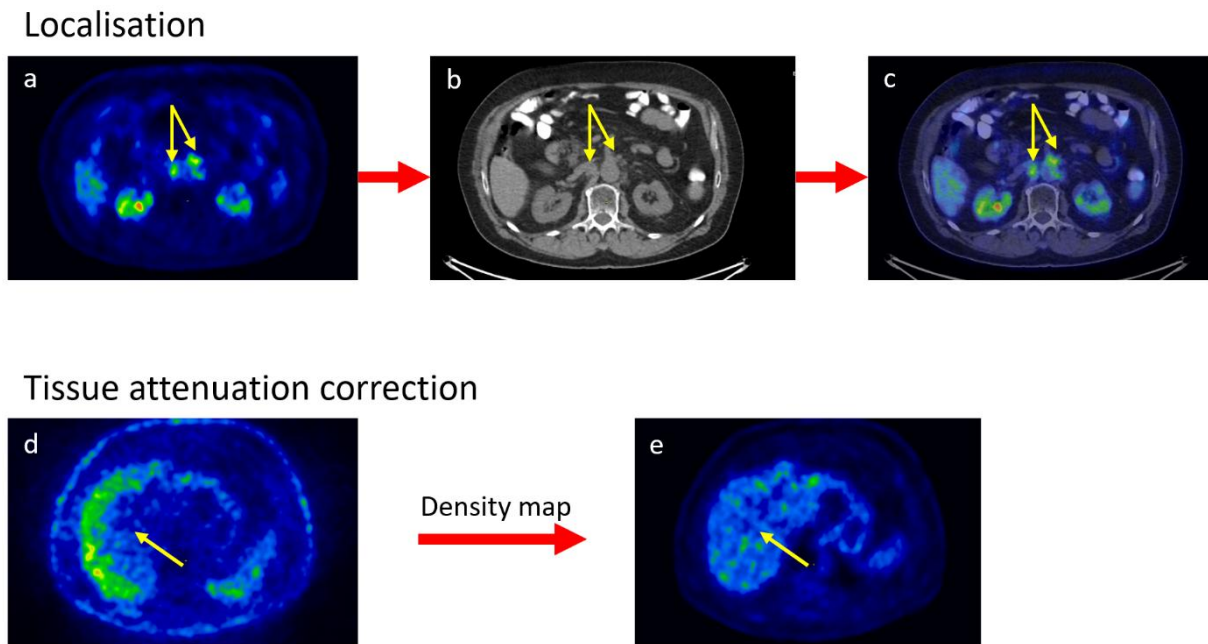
Utility of computed tomography (CT) in positron emission tomography (PET) diagnostics: localisation of small foci of uptake as lymph nodes (a-c) and tissue attenuation correction resulting in a more homogeneous tracer distribution in the liver, approximating the real distribution (d-e). PET/CT data are from the Semmelweis University, display is own work.
